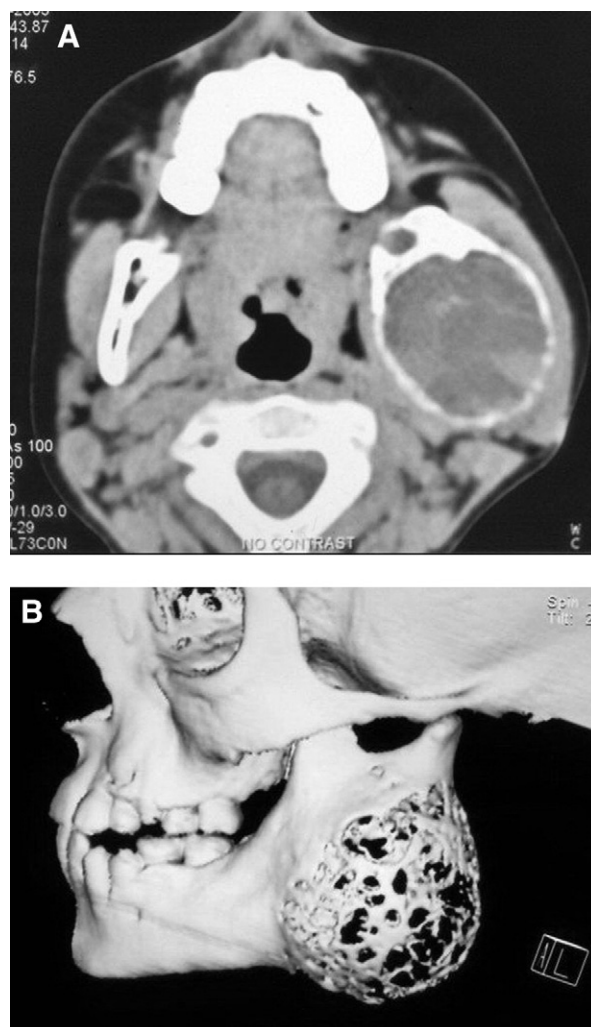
Large aneurysmal bone cavity in a 10-year-old boy. A, Computerized tomography (CT) showing the destructive lesion at the left mandibular ramus. B, Three-dimensional CT presenting the expansion and partial destruction of the cortex of the angle and the ramus.
